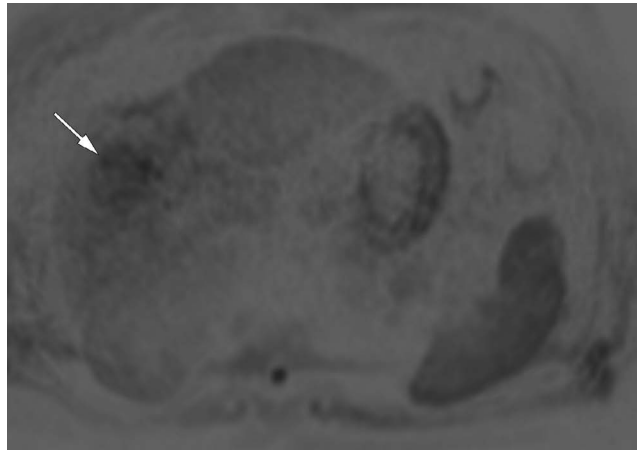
HCC. Annotated. Liver. MRI. DWI (inverted grayscale). $b=500$. Axial plane. An arrow points to a focal lesion in the right hepatic lobe.
